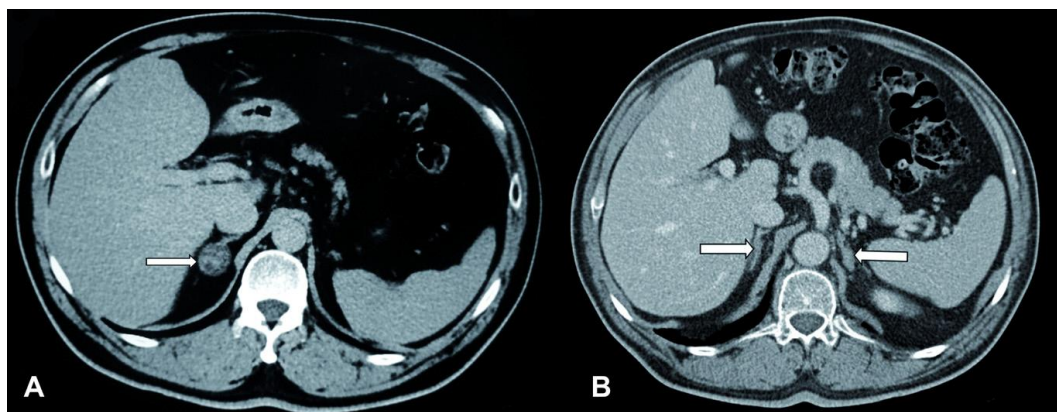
Computed tomography. (A) Right aldosterone producing adenoma (arrow); (B) bilateral adrenal hyperplasia (arrow).
